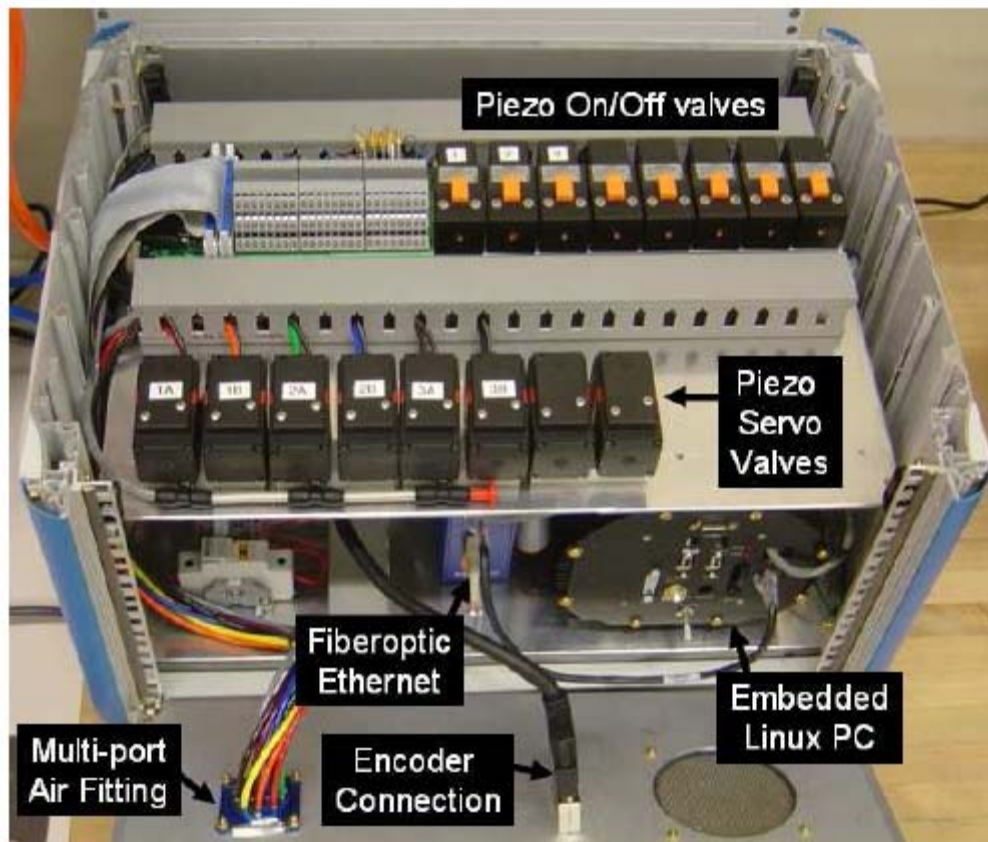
The MRI-compatible robot controller incorporates an embedded computer, fiber optic communications, and piezoelectric valves, and operates inside the scanner room.
